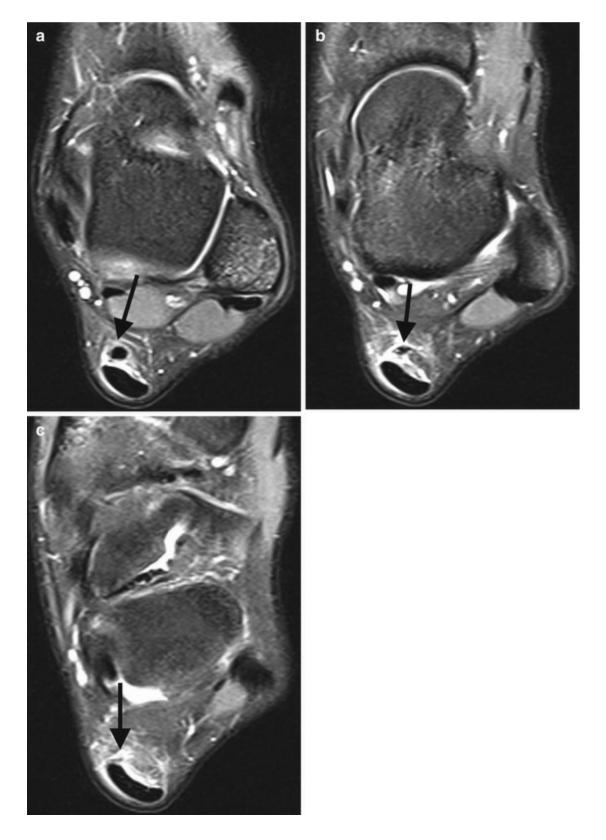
A 15-year-old athlete with acute Achilles tendon pain and an isolated tear of the plantaris muscle tendon. (a–c) Axial fat-suppressed T2-weighted MRI show peritendinous Achilles edema with discontinuity of the distal segment of plantaris muscle tendon (*arrow*)
